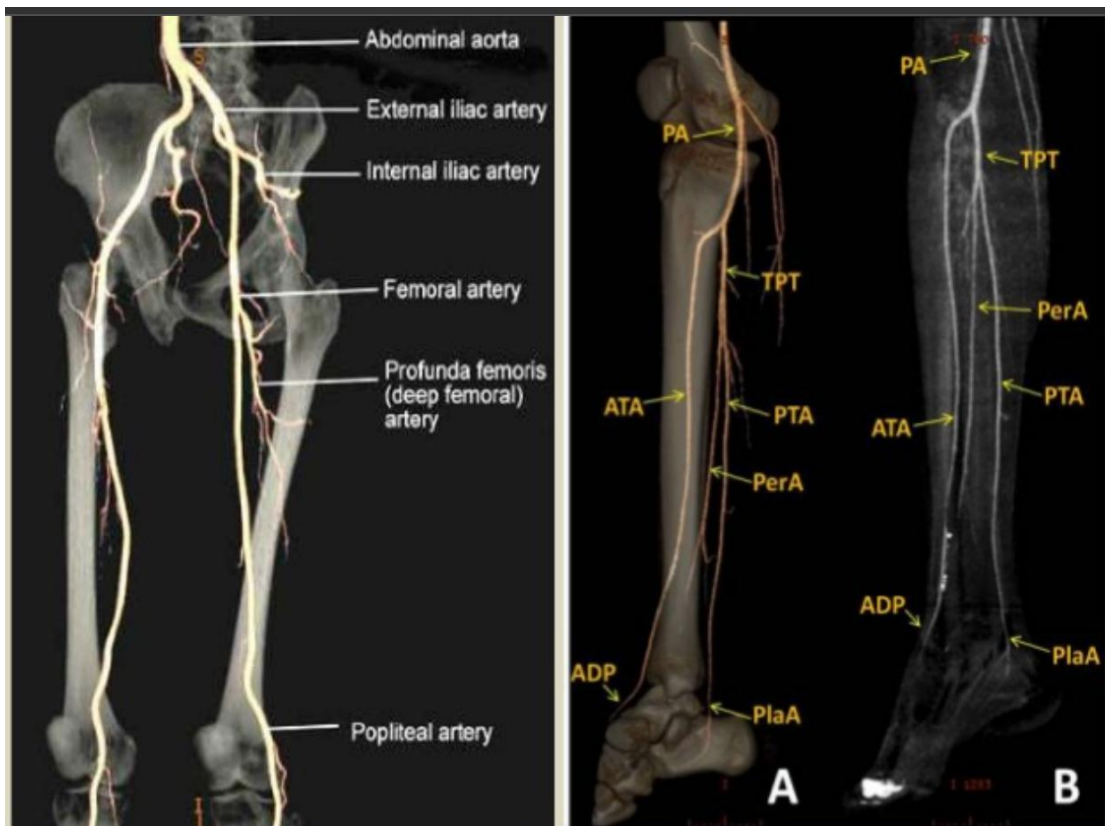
Arteries of the lower limb as seen on CTA.
